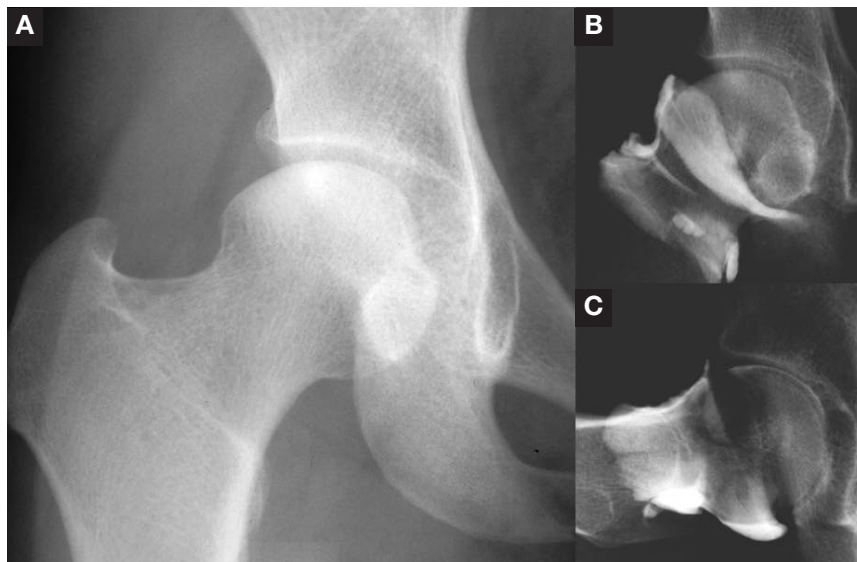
(A) Plain radiograph shows very minimal osteosclerotic change of the weight-bearing portion of the femoral head. (B, C) The arthrography showed no findings of torn labrum or any free bodies.
